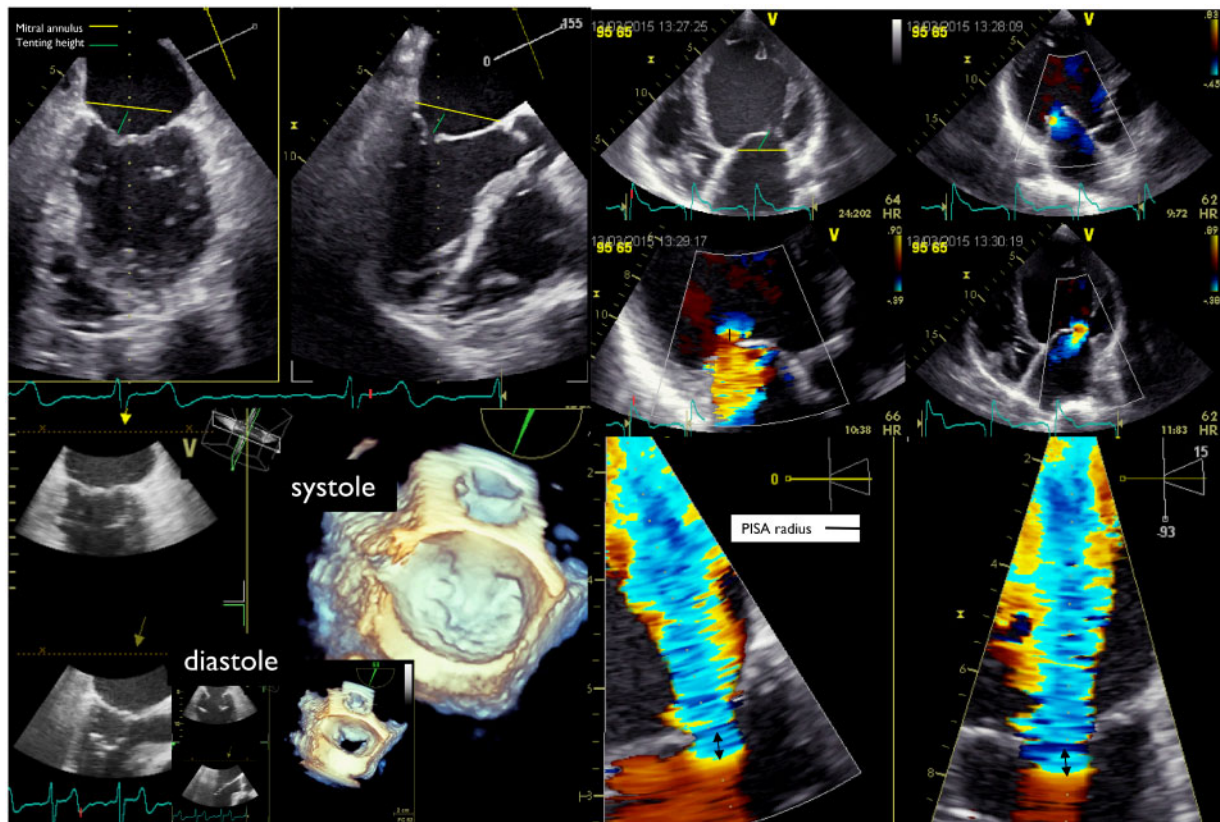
A woman 75 years old, idiopathic DCM, who justified a cardiac resynchronization therapy and an ICD. After few years, despite an OMT she is still NYHA II+ and recently hospitalized for acute HF. The transthoracic echocardiography completed by a transoesophageal exam allows to describe the spherization of the left ventricle (LVEF 35% and LV end-diastolic diameter 64 mm). The tethering effect related to this LV remodelling on both mitral leaflets. The leaflets are thin without any large indentation, without any calcification, and the regurgitant jet is greater than 45 mL/beat (regurgitant orifice area $>20 \text{ mm}^2$) and maximal in regard to A2P2.
